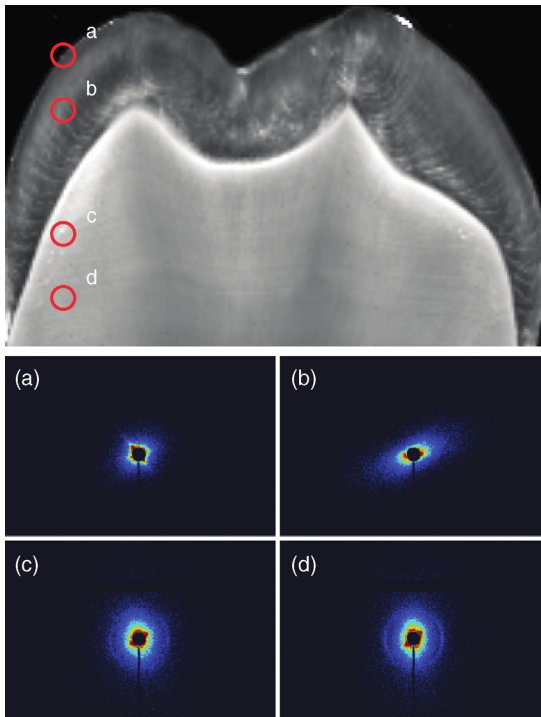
The tooth slice several hundred micrometer thick is scanned through the collimated X-ray beam in x and y directions (cf. Figure 12.2). At each position a SAXS
